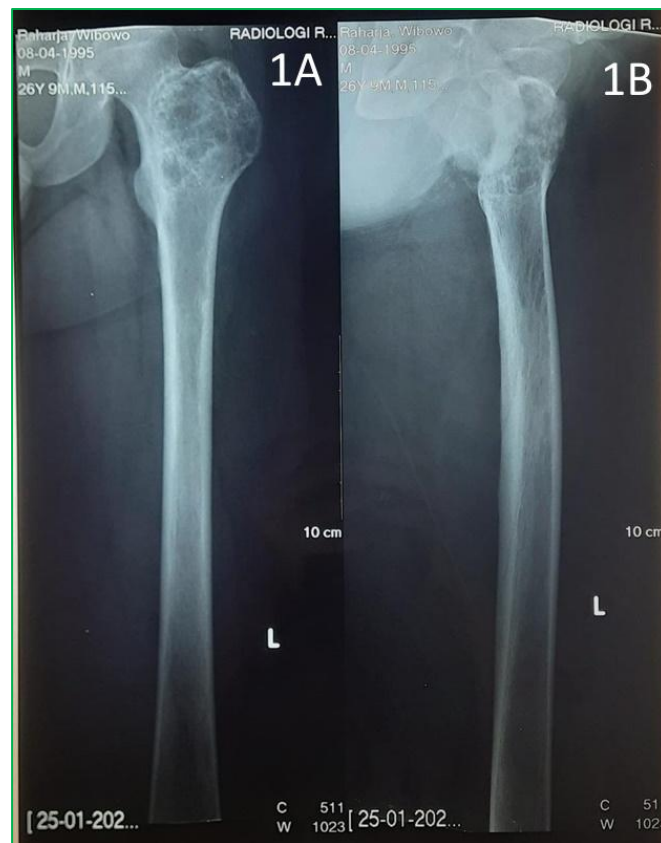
X-ray on left femur before and after injection
